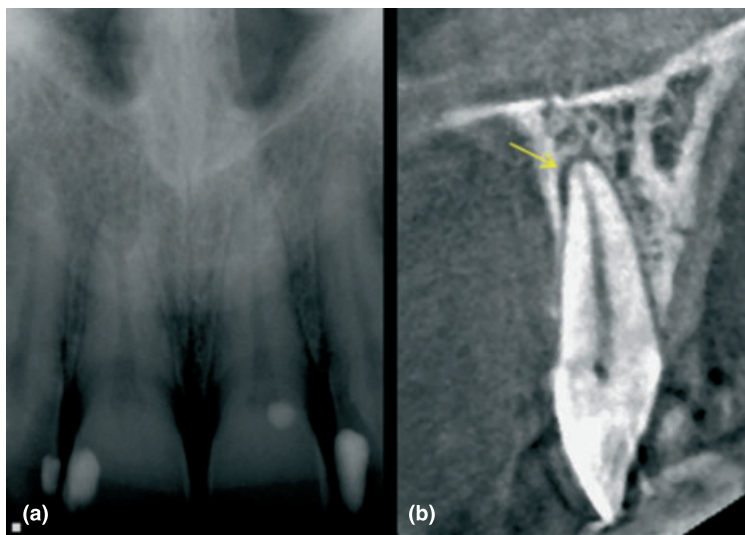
(a) Periapical radiograph of a patient who has been complaining of an intermittent dull ache. Clinical and special investigations are unremarkable. A periapical radiograph of the maxillary central incisor teeth reveal a normal periapical appearance. (b) Cone beam computed tomography scans reveal a periapical radiolucency (yellow arrow) associated with the UL1, this tooth was root treated after and the patient symptoms resolved.
